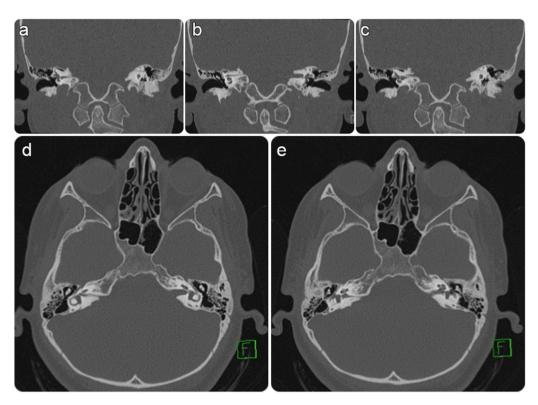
Computed tomography images demonstrating a narrow duplicated IAC of the right temporal bone. The IAC is divided by a bony septum into the superior and inferior portions. The superior portion ends in a wide connection to the facial canal and a narrow connection to the vestibule. The posterior portion ends in a narrow connection to the cochlea and vestibule.
